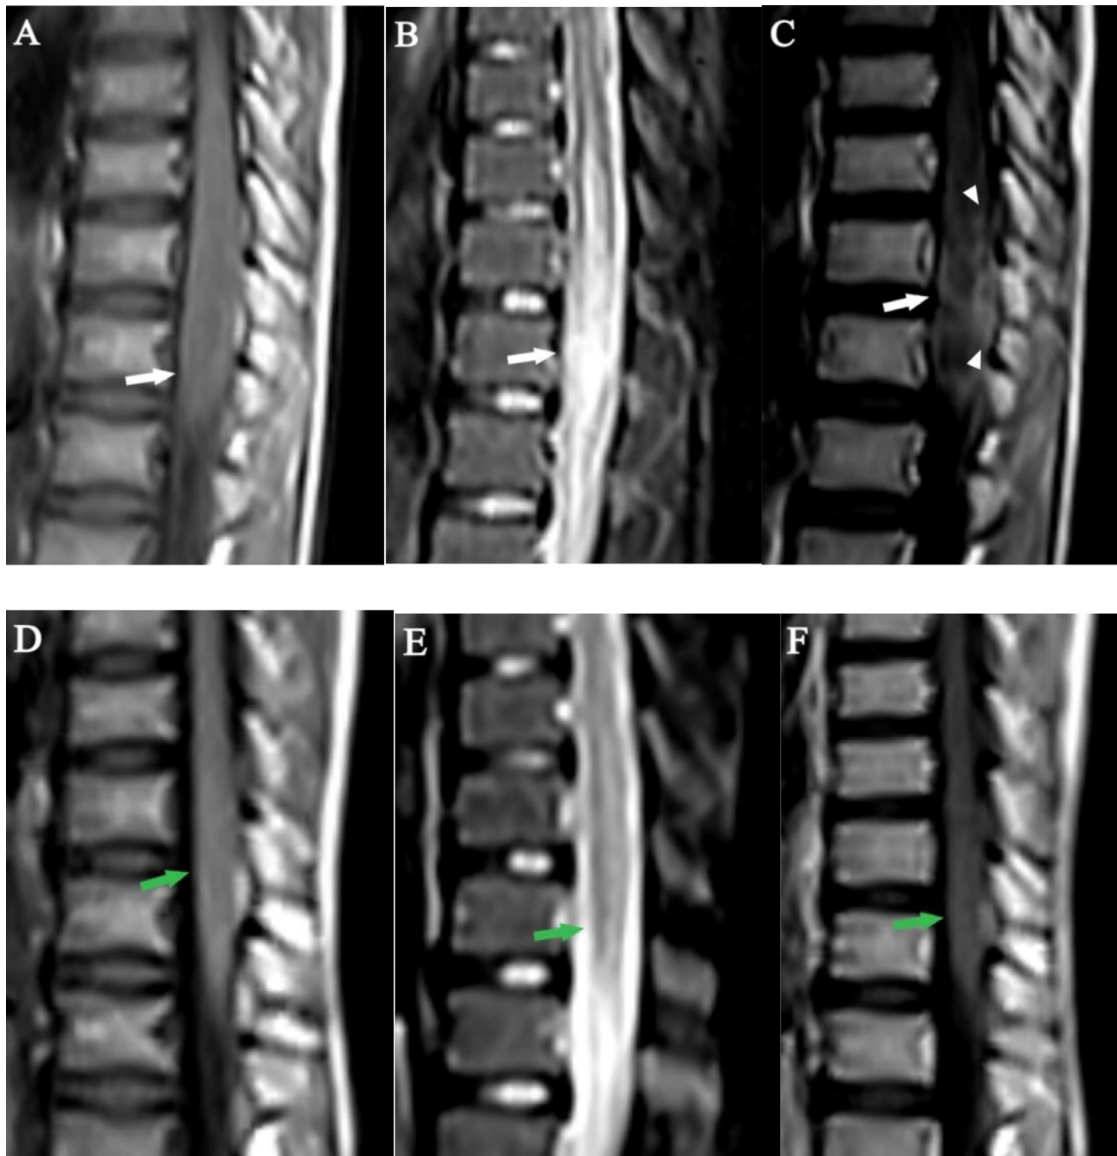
Sagittal lumbo-sacral MRI at initial presentation in T1W (A), T2W (B), and T1 C+ (C) sequences show conal expansion with high T2 signal and surrounding edema (white arrows in A and B). The post-contrast image shows the expanded cord (C) with a peripheral linear-like and nodular type of enhancement giving the arborized appearance of enhancement. On the 5 month post-treatment follow-up MRI in T1W (D), T2W (E), and T1 +C (F) sequences, significant reduction in the expansion of the conus and enhancement were seen (green arrows on D-F).
